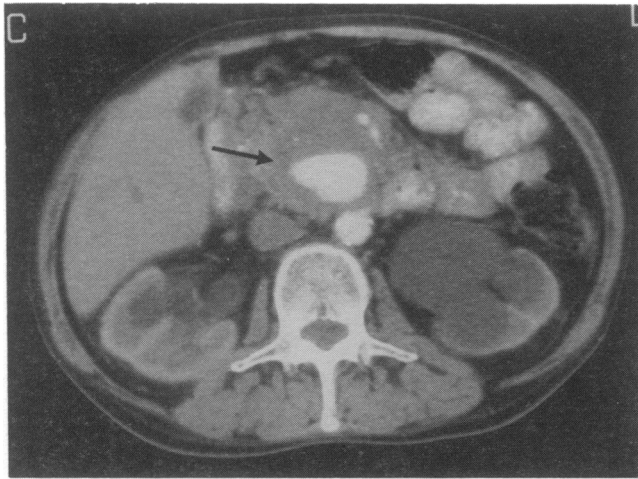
CT scan showing a false aneurysm of the pancreaticoduodenal artery (after pancreatitis).
